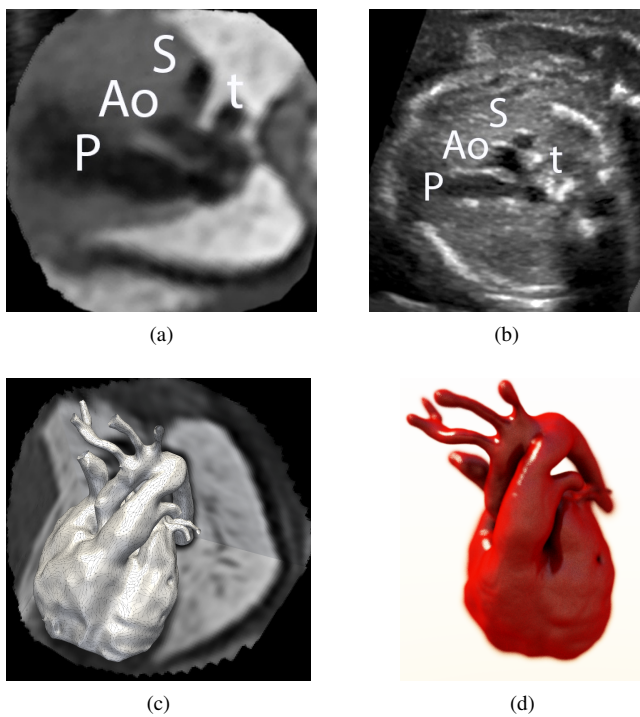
Validation of a motion compensated volume (a) with a standard fetal “three vessel view” from ultrasound (b). P = pulmonary artery, Ao = aorta, S = superior caval vein, t = trachea. PVR allows to generate highly accurate 3D models (c) [LKvA\*16, WVV\*05], which can be rendered photorealistically [KPB12] for educational and intervention planning purposes.
